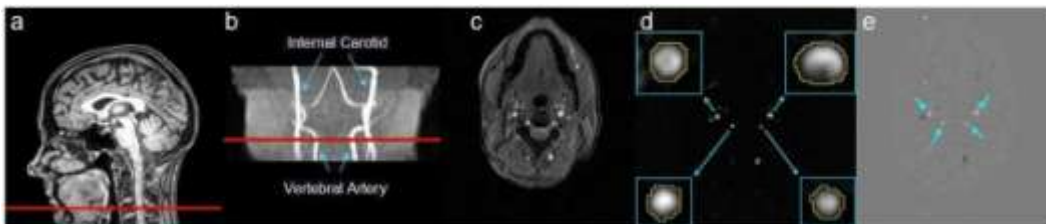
Phase-contrast (PC) velocity MRI of Internal Carotid Arteries (ICA) and Vertebral Arteries (VA). (a) Location of the slice of PC
